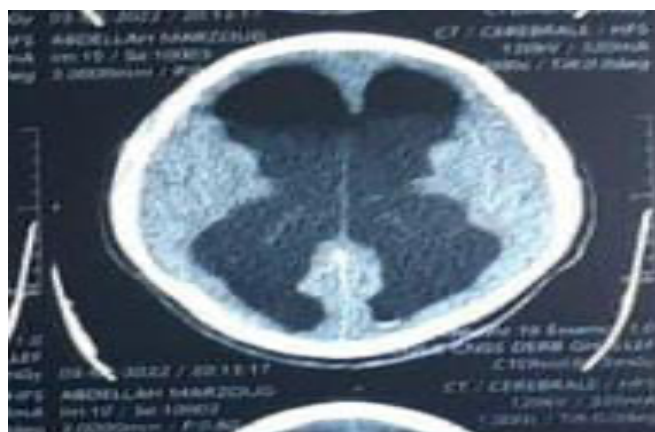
CT brain showing right side of the ventricles after ETV.
